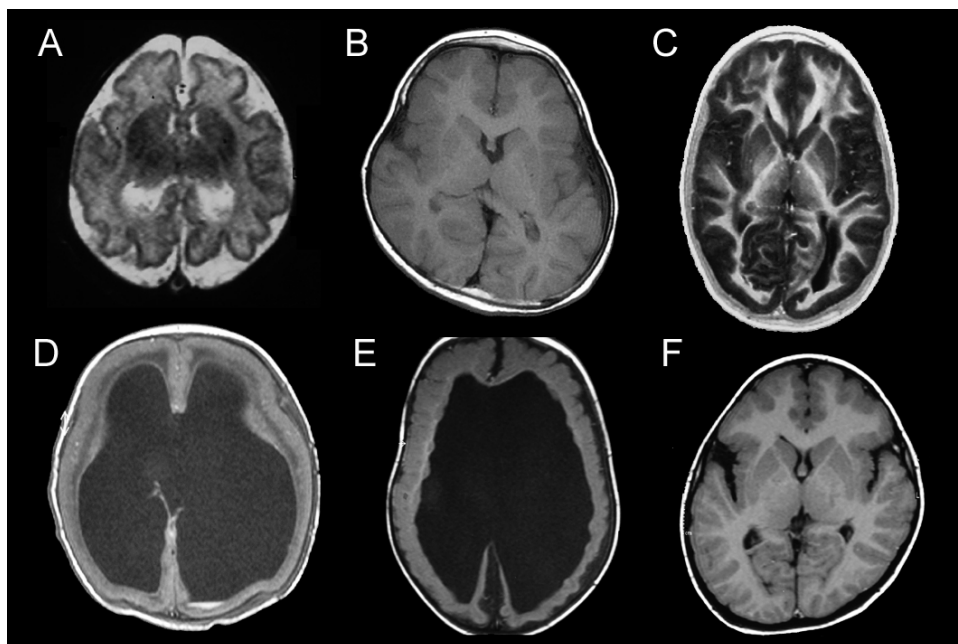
Magnetic resonance images of key patients with a definite diagnosis without known molecular defects. All images are T1-weighted, except where indicated. A, T2-weighted image of patient 2, a boy aged 29 months with a simplified gyral pattern and high clinical function. A reduced number of gyri, shallow sulci, and normal cortical thickness are seen. B, Patient 25, a girl aged 6 months with Baraitser-Winter syndrome. The cortex in the frontal lobes is thickened. C, Patient 26, a boy aged 6 years with a muscle-eye-brain-type syndrome. Smooth gyration in the occipital lobes is evident. D, Patient 36, a newborn boy with Walker-Warburg syndrome. Gyration is absent and the ventricles are enlarged. E, Patient 68, a boy aged 3 years with Adams-Oliver syndrome. Periventricular heterotopic nodules of gray matter and irregularity of the gyral pattern suggest polymicrogyria (PMG). F, Patient 71, a boy aged 5 years with merosin-negative muscular dystrophy. Irregular gyration is seen in the frontoparietal regions, most pronounced around the sylvian fissure, suggestive of PMG.
